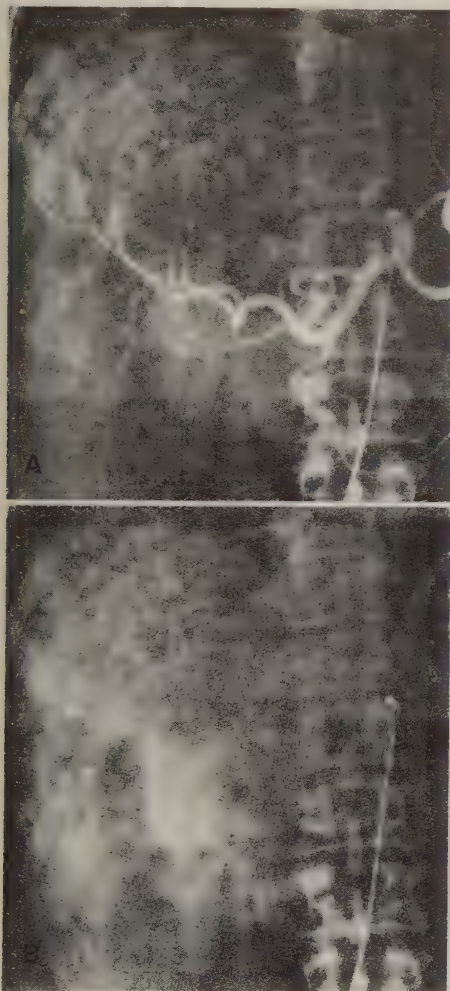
Combined single mass and multi-nodular metastasis of carcinoid tumor. Angiographic findings in the large mass mimic hepatoma. A Arterial phase; B parenchymal phase; C non-enhanced CT examination shows slightly reduced density in large tumor; D contrast-enhanced CT examinations gives improved outlining of tumor with increased density in periphery of tumor.
